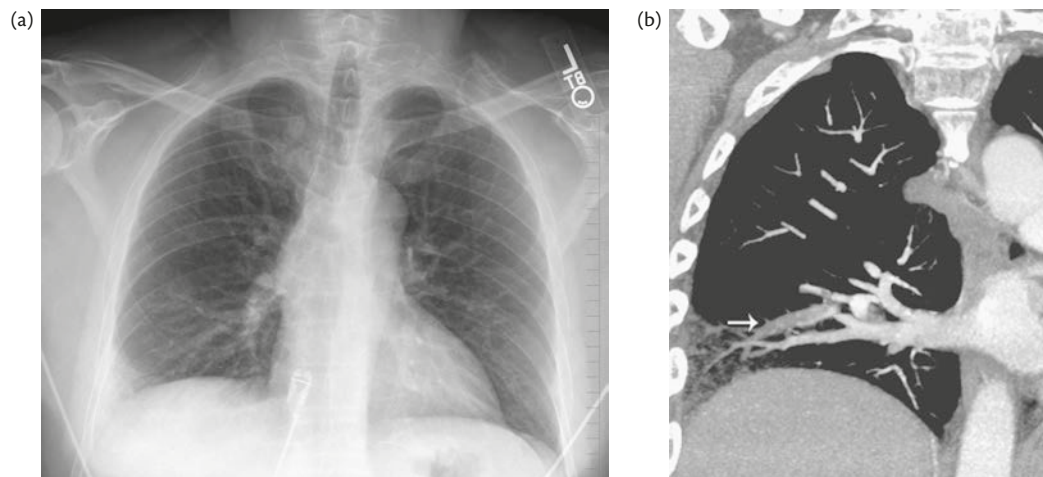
Case 1. (a) X-ray; (b) CT scan.
